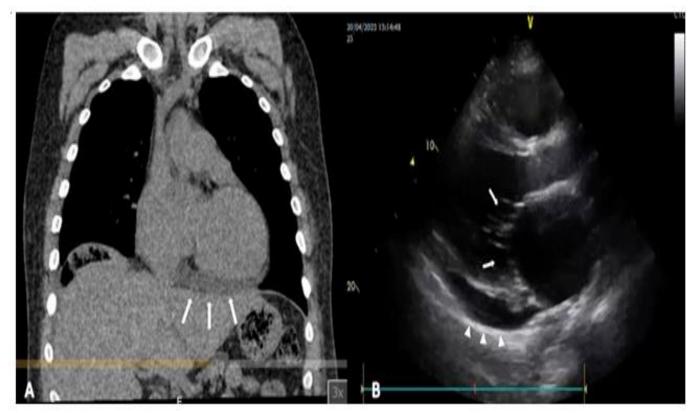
A) Simple chest tomography in coronal section cardiomegaly associated with pericardial effusion is observed (Arrows). B) TTE that shows in the long parasternal axis an evident myocardial dilation associated with a dome-shaped mitral valve in the left ventricle (Arrows), as well as moderate pericardial effusion (Arrowhead).
